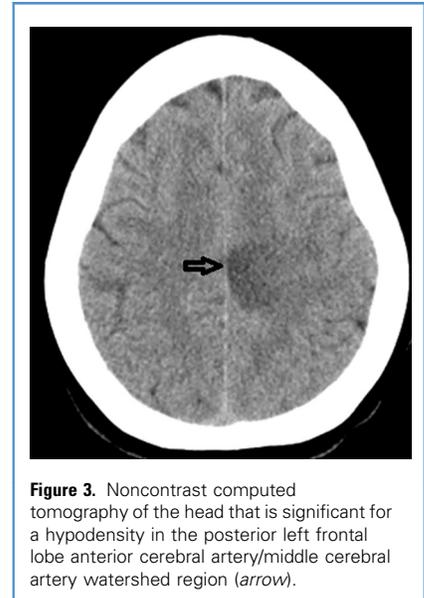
Noncontrast computed tomography of the head that is significant for a hypodensity in the posterior left frontal lobe anterior cerebral artery/middle cerebral artery watershed region (arrow).
